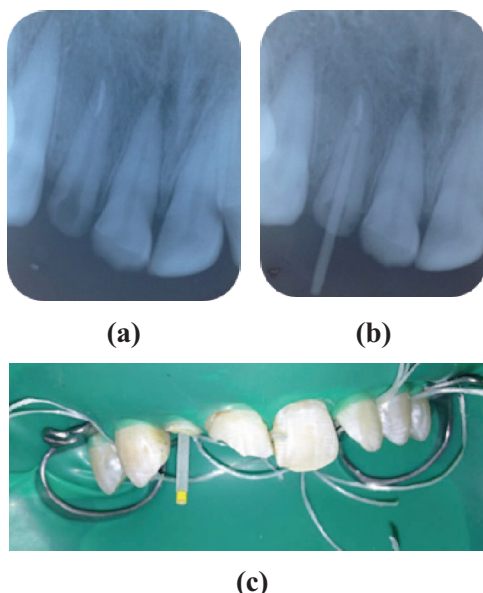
the post channel preparation radiography (a); matching the post radiographically (b); matching the post (c)
